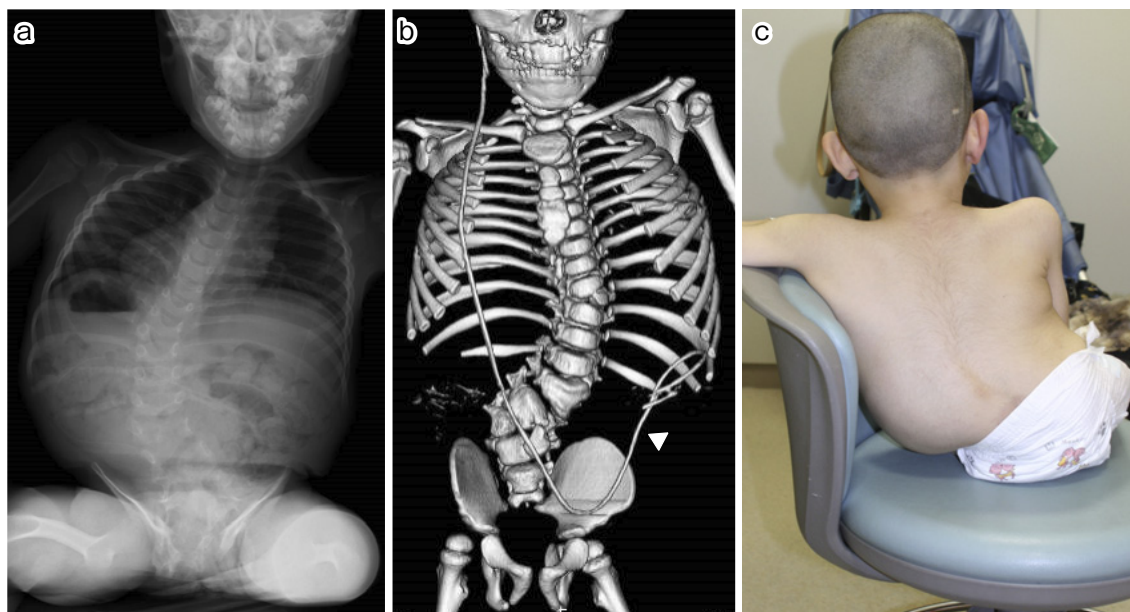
a: X-ray images; b: 3D-CT images showing the relation between the congenitally deformed spine and the pelvis (Renshaw type III). White arrowhead indicates a ventriculoperitoneal shunt tube; c: clinical photography.
